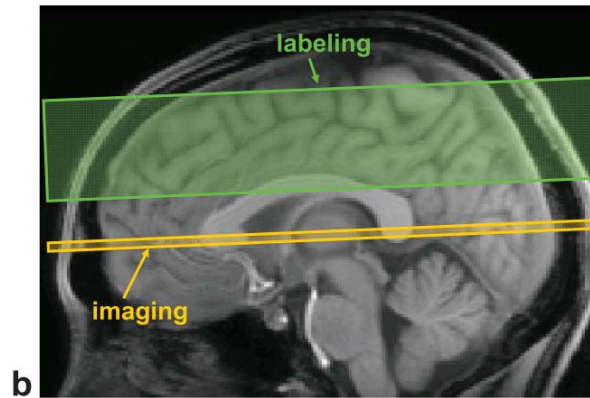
The T_2 -relaxation-under-spin-tagging (TRUST) MRI sequence.
